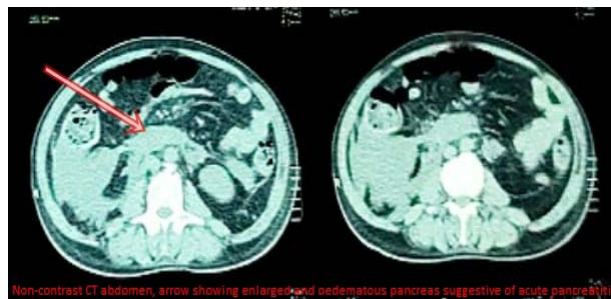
Non-contrast CT abdomen, arrow showing enlarged and oedematous pancreas suggestive of acute pancreatitis
